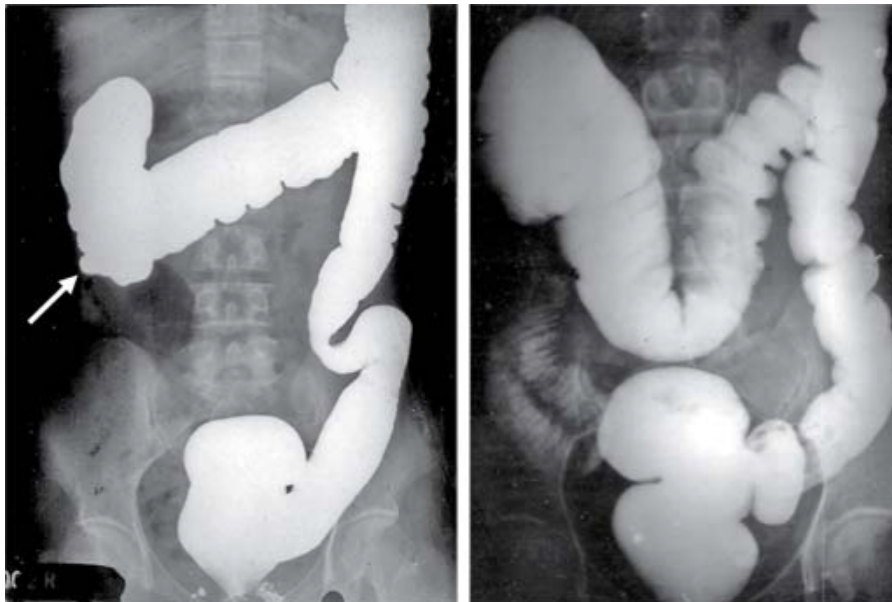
Pulled-up caecum, obtuse ileocaecal angle— ileocaecal tuberculosis in barium study X-ray.
